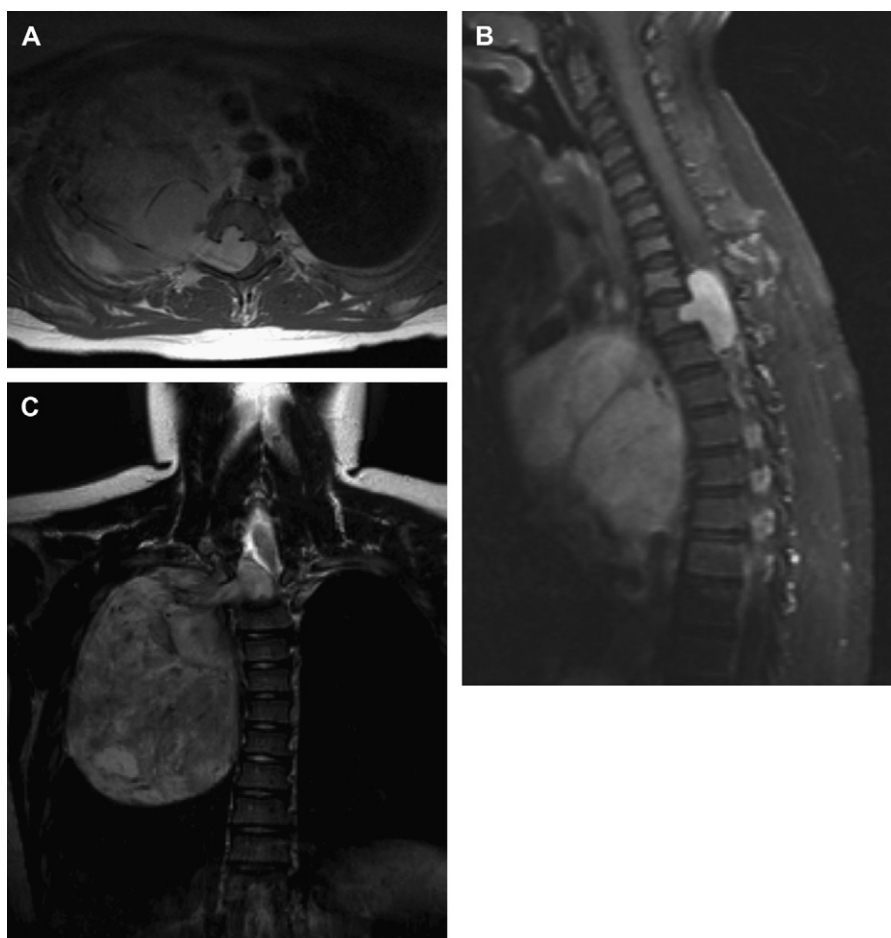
T1-weighted MR images with gadolinium of a classic dumb-bell-shaped neuroblastoma with significant extension into the chest cavity and spinal canal shown in (A) axial, (B) sagittal, and (C) coronal planes.
